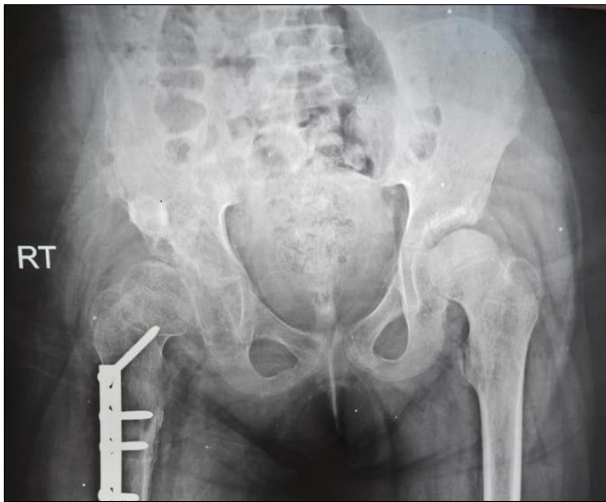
Pre-operative x-ray shows residual hip dysplasia at right side
